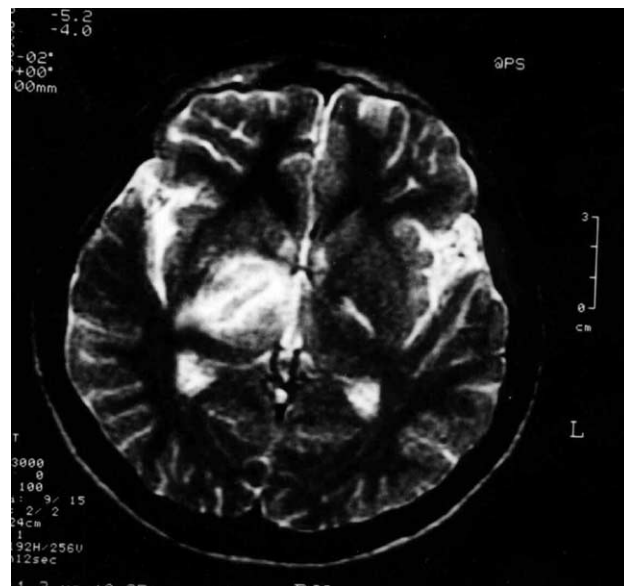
In the second attack of the patient's illness, foci of increased signal intensity on the T2-weighted images.
